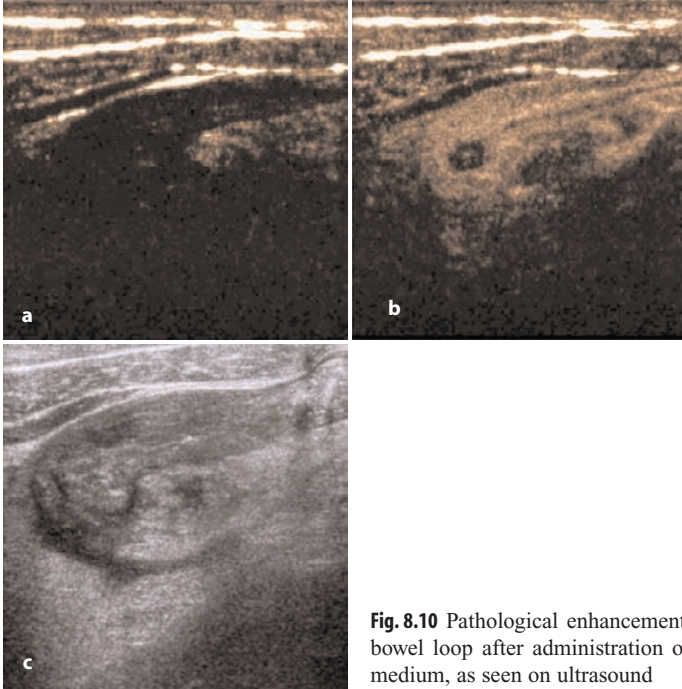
Pathological enhancement of a thickened small bowel loop after administration of intravenous contrast medium, as seen on ultrasound
